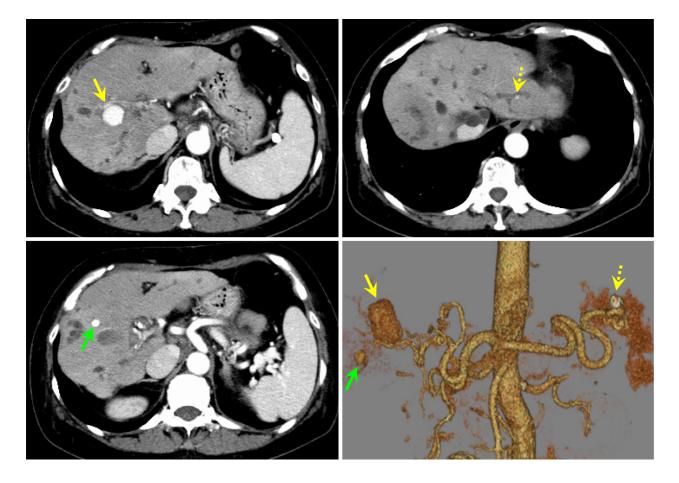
Contrast-enhanced computed tomography scan of the abdomen at diagnosis. Intrahepatic artery aneurysms were suspected as nodular contrast-enhanced areas approximately 20 mm in size appeared in S 7/8 (yellow arrow), 7 mm in size in S 5 (green arrow), and 4 mm in size in the lateral segment (dotted yellow arrow).
